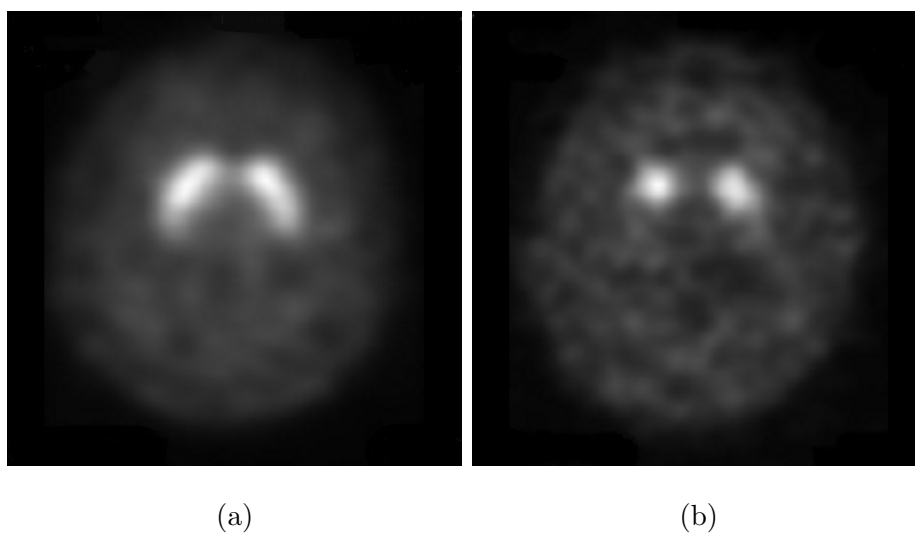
SPECT scans showing examples of (a) Non-PD patient and (b) PD patient
